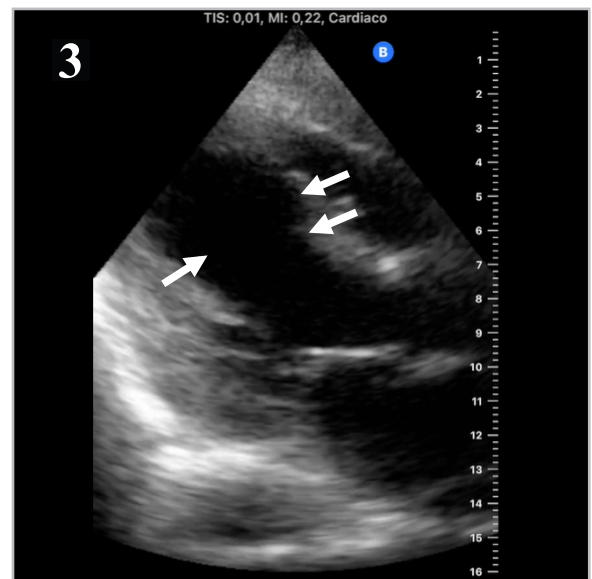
Parasternal long axis view showing left ventricular dilation as an indirect sign of increased pressure in the heart chambers.
